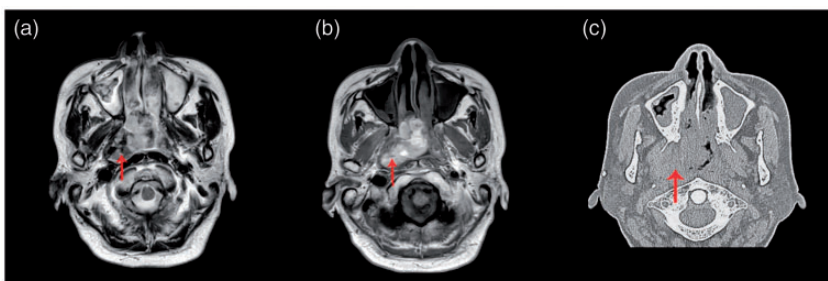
(a) On magnetic resonance imaging, a T2-weighted image shows masses with a low-intensity signal (arrow). (b) A T1-weighted image shows masses with a high-intensity signal (arrow). (c) An axial computed tomography scan shows a right nasopharyngeal mass (arrow).
